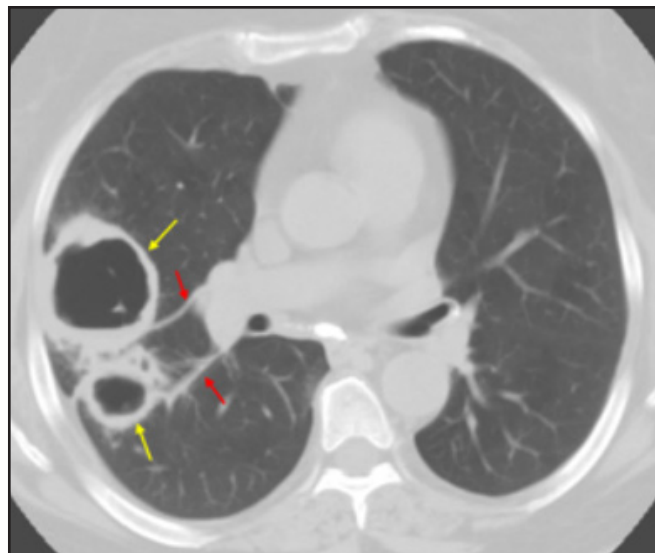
Granulomatosis with polyangiitis. Axial contrast-enhanced CT image in a patient with history of granulomatosis with polyangiitis. This image demonstrates multiple pulmonary cavities (yellow arrows) with feeding vessels (red arrows).
